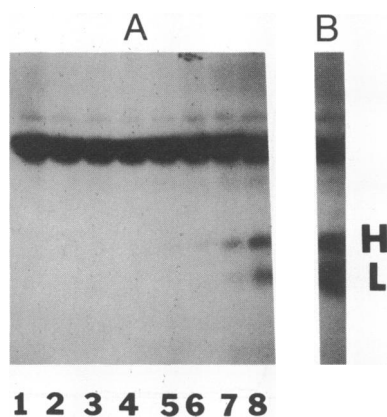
Autoradiograph obtained on NaDodSO₄/PAGE under reducing conditions of serial subsamples from a reaction mixture containing ¹²⁵I-factor VII and unlabeled factor X. The gel was dried and exposed to x-ray film for 72 hr at -80°C. (A) Lanes 1-8 represent subsamples removed at the following intervals: zero time, 1 min, 1.5 min, 2 min, 3.5 min, 5 min, 7.5 min, and 10 min. (B) Autoradiograph of the factor VIIa preparation described in the legend of Fig. 4. H and L denote the heavy and light chains, respectively, of factor VIIa. The film was overexposed purposefully to show that activation of factor VII is not measurable by this technique until at least 3.5 min after reactions have been initiated with calcium.
